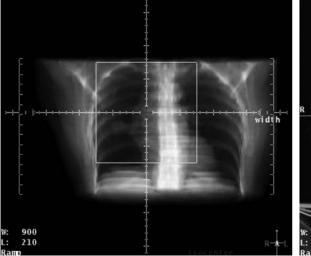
Coronal digital reconstructed radiograph (DRR) (*left*) showing placement of an anterior field isocenter; and an axial CT slice with placement of the isocenter at depth in the patient
